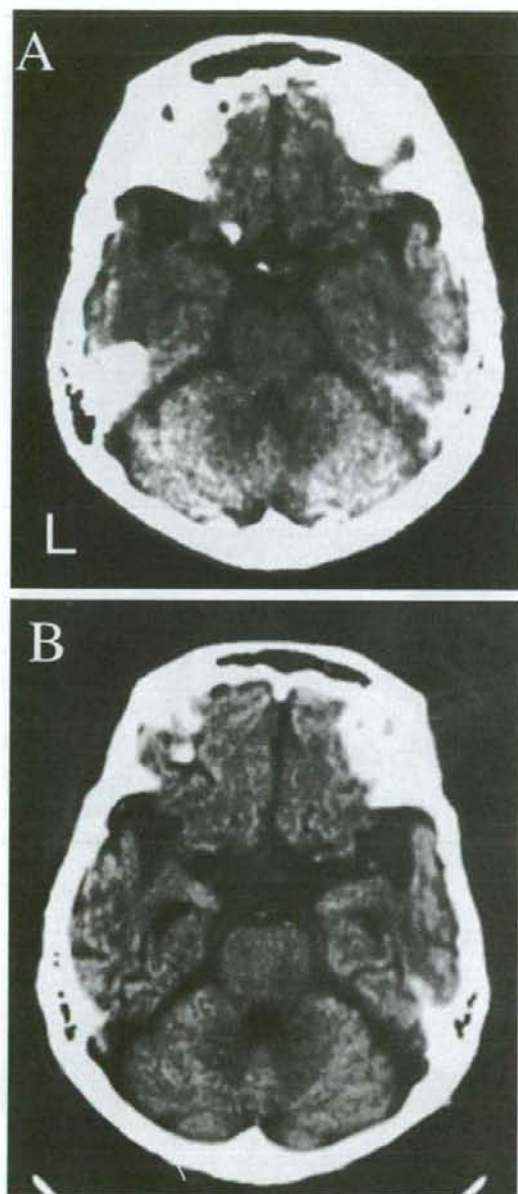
CT scan of the patient at the age of 76 years (8 years before death) (A) and at 84 years (2 months before death) (B), showing moderate diffuse atrophy of the limbic cortex and moderate enlargement of the inferior horn of both lateral ventricles.
